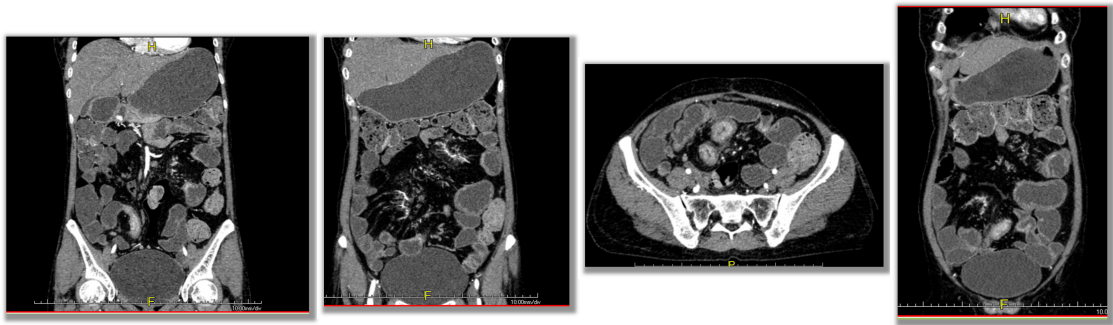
Coronal and axial CT enterography images showing increased multi segmented mucosal hyper enhancement, wall thickening of ileal loops(skip lesions) and increased mesenteric vascularity(COMB'S SIGN) and fibro fatty proliferation suggestive of crohn's disease
